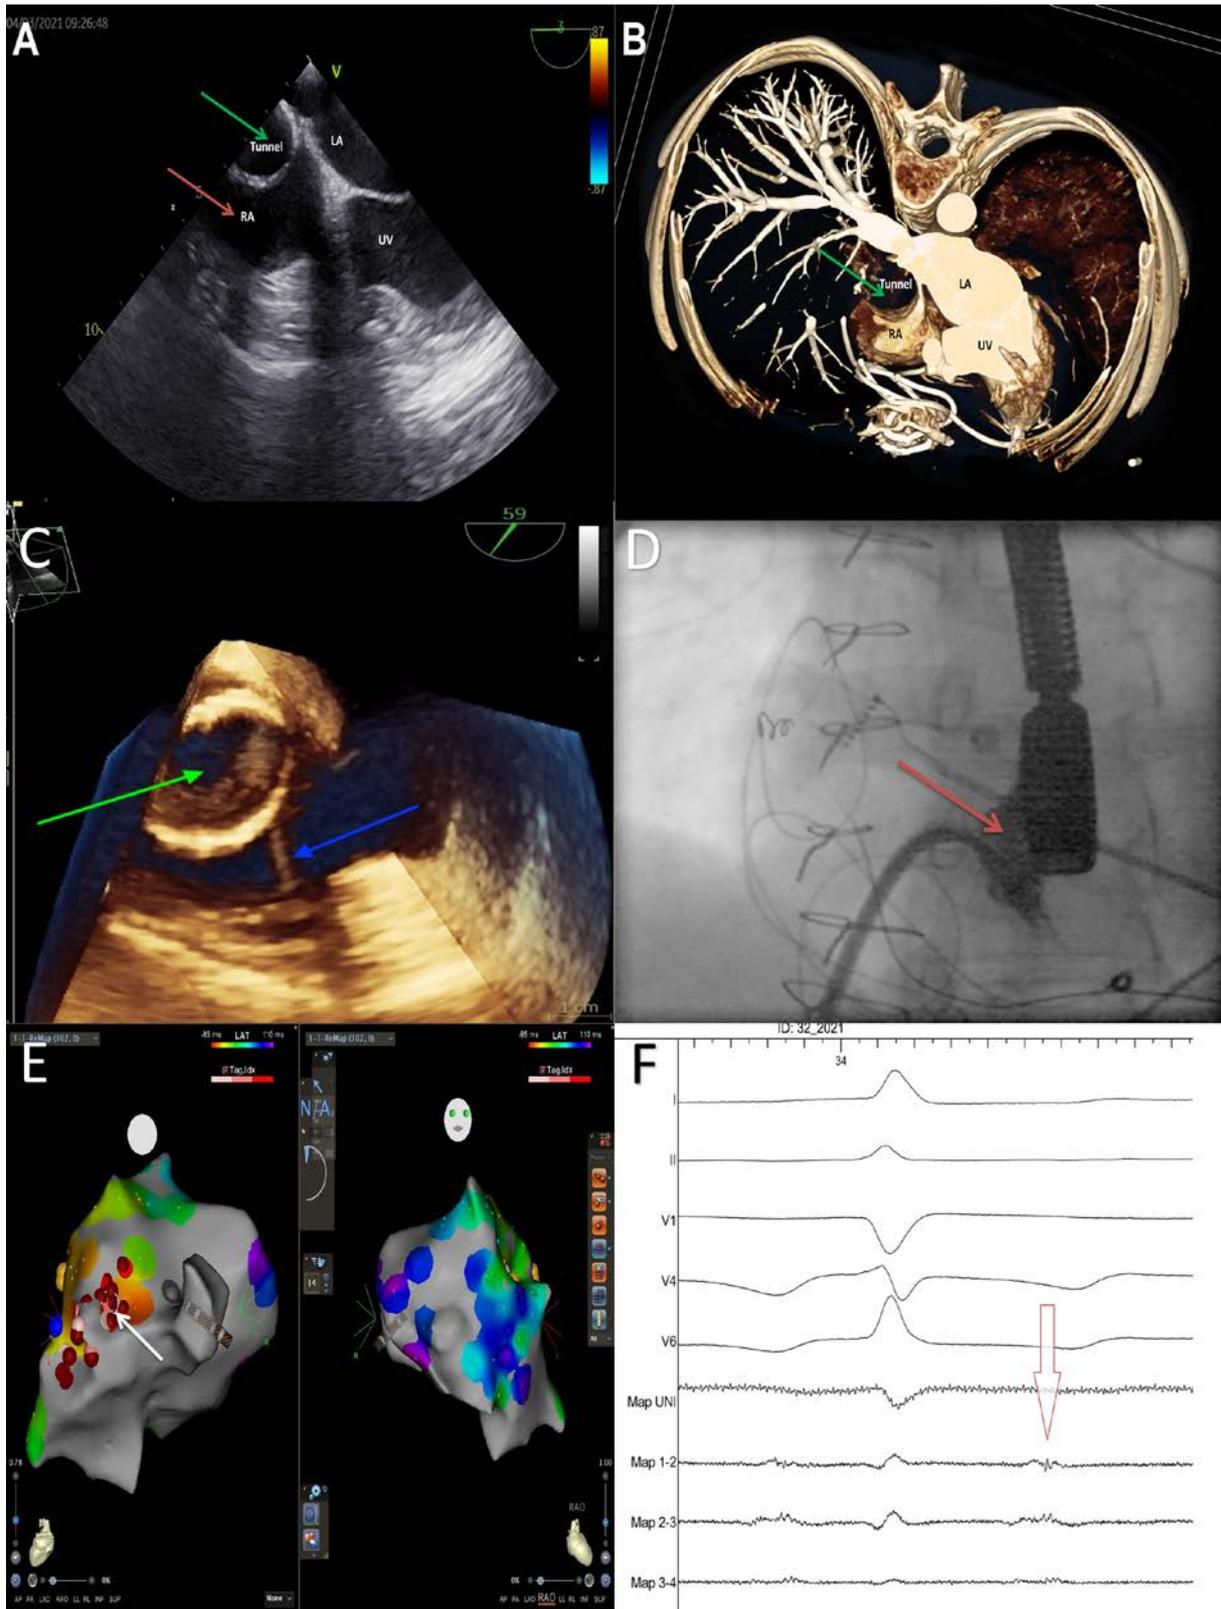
A. Transesophageal echocardiographic visualization of the tunnel (green arrow) and right atrium (red arrow). B. Computed tomography visualization of the intraatrial tunnel (green arrow). C. Three-dimensional transesophageal echocardiographic visualization of the tunnel (green arrow), right atrium (red arrow), and transeptal sheath (white arrow) after
